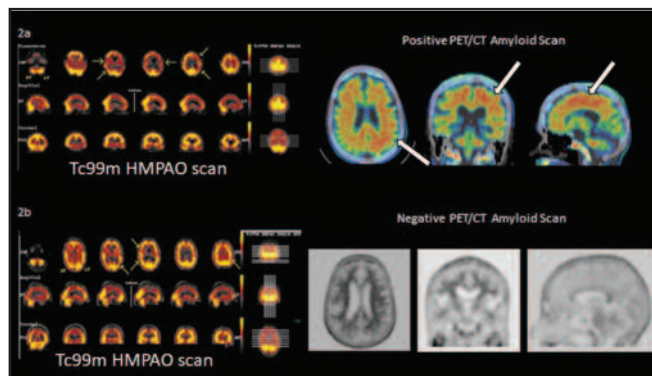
Multiplanar Imaging of Tc99m-HMPAO SPECT and PET/CT Amyloid Scans.
